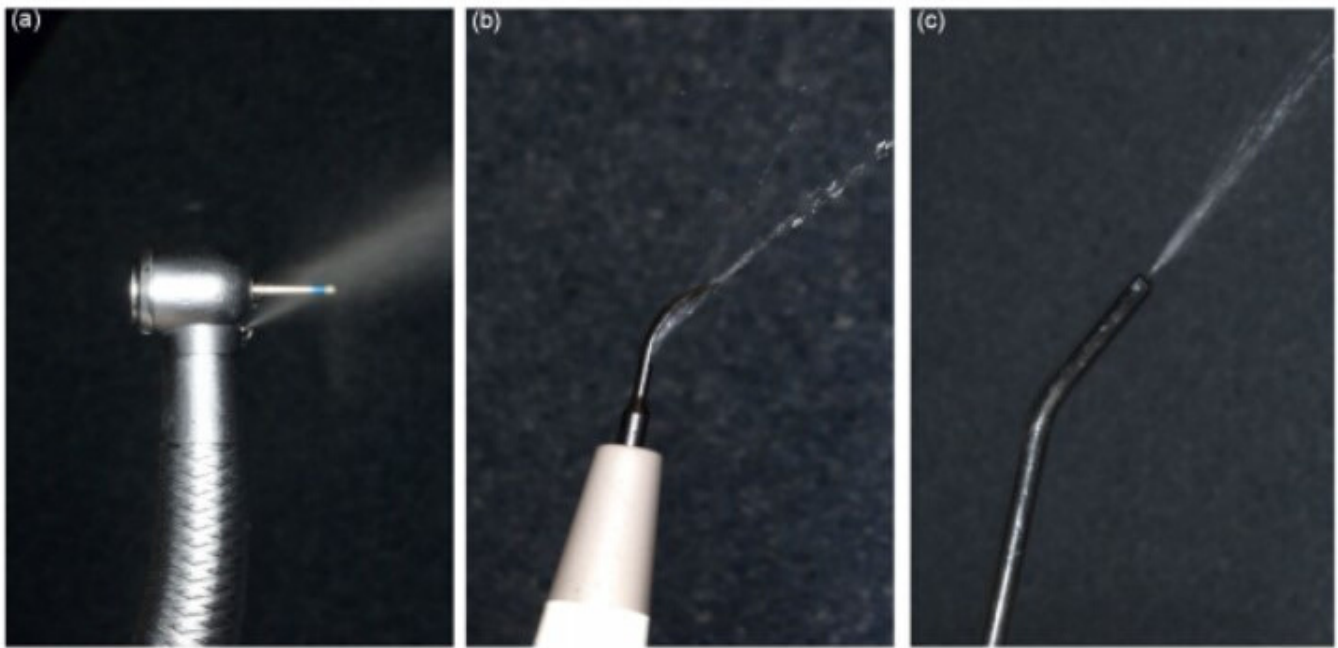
Aerosols generated by dental high-speed handpiece (a), ultrasonic scaler (b), and air-water syringe (c)
